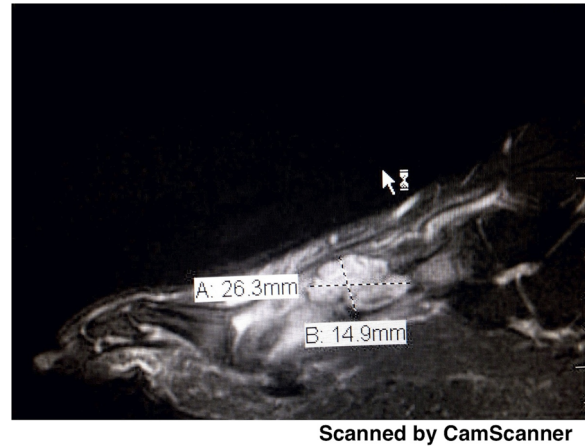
Left foot MRI showing an expansile lesion within the mid-distal shaft of the left third metatarsal.
